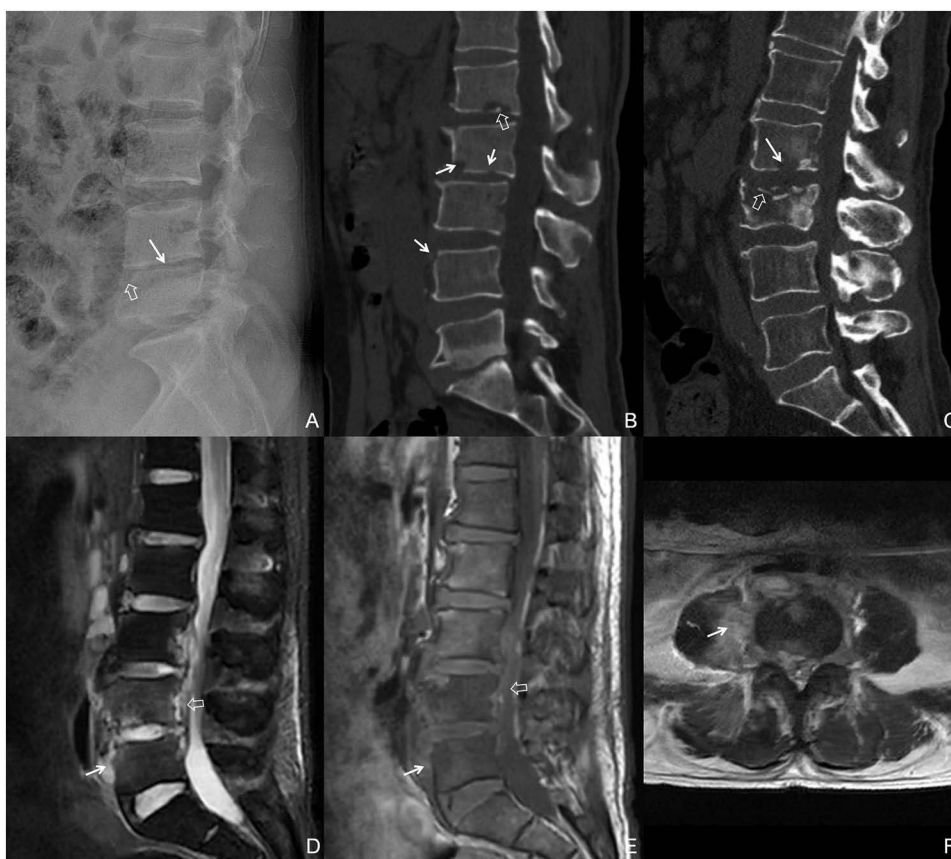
(A) sample of the image analysis performed using Radiant viewer. Male, 32 years old. The lateral X-ray of the lumbar spine showed stenosis of the intervertebral space between lumbar vertebrae 4 and 5 (solid white arrow), and bone destruction at the anterior upper edge of the fifth lumbar vertebra (hollow white arrow) (A); Male, 52 years old. Sagittal CT reconstruction of the lumbar vertebrae indicated that bone destruction of the lumbar vertebrae simultaneously involved the anterior and middle columns of the spine (solid white arrows). Stenosis of the L5-S1 intervertebral space, worm-eroded bone destruction of the endplates of the fifth lumbar vertebra and the first sacral vertebra, and hardening of the surrounding bone. Punctate high-density dead bone (hollow white arrow) within the bone destruction under the endplate of the lower edge of the first lumbar vertebra (B); Male, 56 years old. Sagittal CT reconstruction of the lumbar vertebrae indicated multiple bone destruction in the second and third lumbar vertebrae (solid white arrows), bone interruption of the endplate at the upper edge of the third lumbar vertebrae, and compression fracture of the third lumbar vertebrae (hollow white arrows) (C); Male, 64 years old. The sagittal position of the fat suppression sequence on MRI T2WI indicated high signals within the 3rd, 4th, and 5th lumbar vertebrae. Granulomas under the anterior longitudinal ligament (solid white arrow) and under the posterior longitudinal ligament (hollow white arrow) showed slightly high signals (D); MRI T1WI sagittal position indicated low signal within the 4th and 5th lumbar vertebrae, while granulomas under the anterior longitudinal ligament of the vertebral body (solid white arrow) and under the posterior longitudinal ligament of the vertebral body (hollow white arrow) showed equal-slightly high signal (E); The transverse section of the fat suppression sequence on MRI T2WI showed high-signal granulomas under the anterior longitudinal ligament and posterior longitudinal ligament, as well as a high-signal abscess in the right psoas major muscle (solid white arrow) (F).
